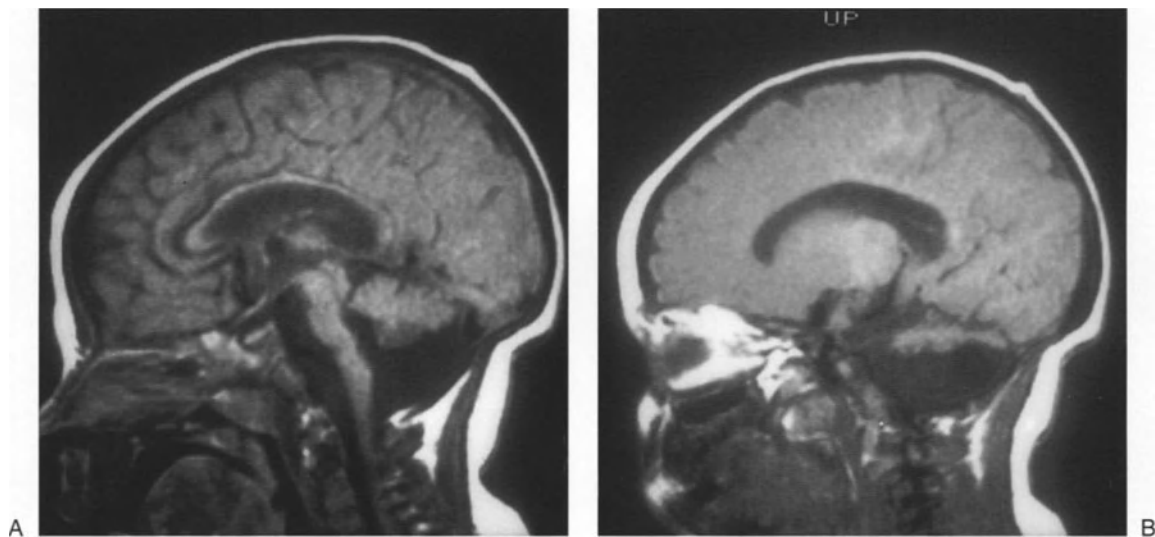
Hypoplasia of the cerebellar vermis and hemispheres. These sagittal (A) and parasagittal (B) MRI T1
